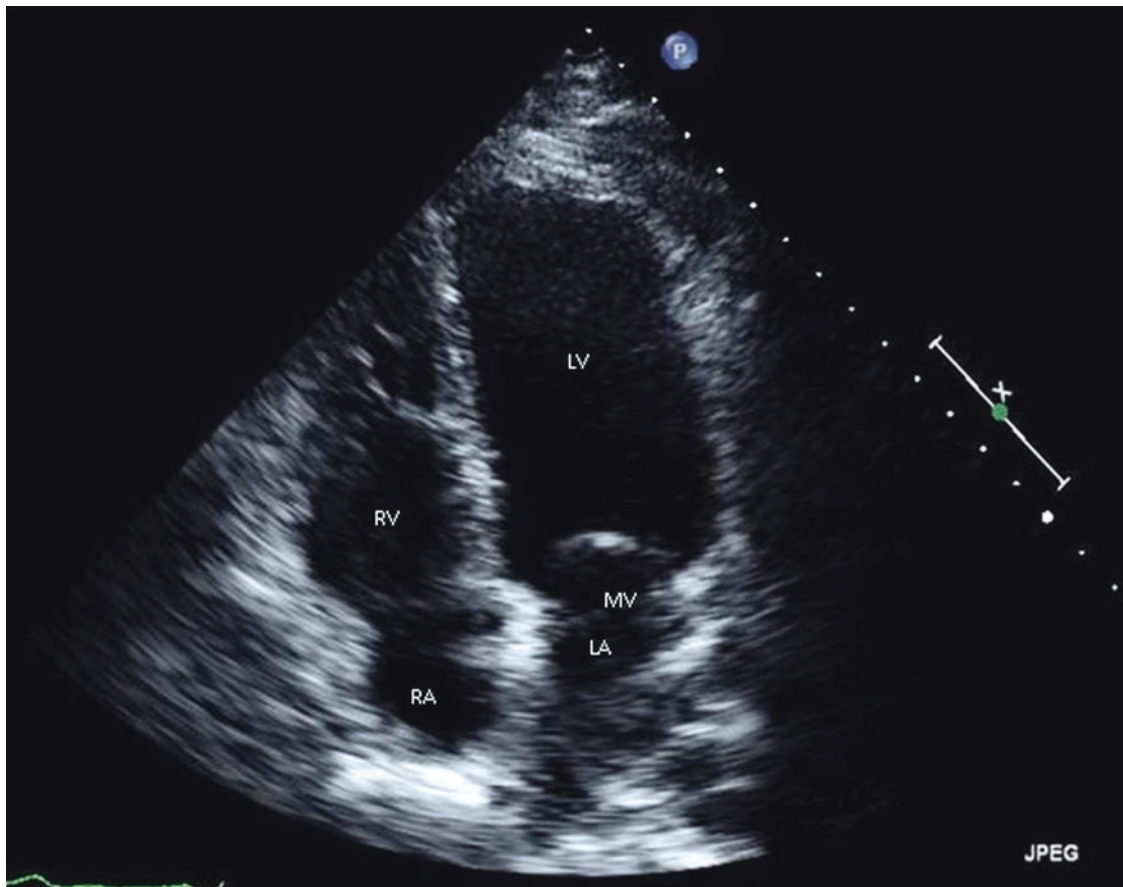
Apical four-chamber view
